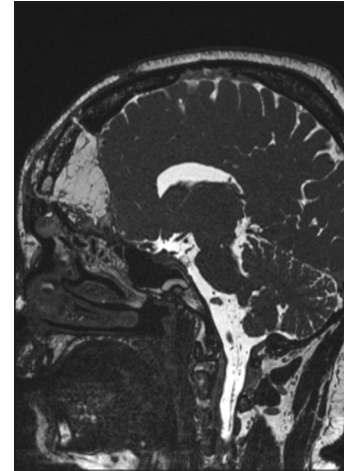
Three-month postoperative sagittal T2-CISS 3D magnetic resonance imaging showing the posterior ethmoidal space, filled with free fatty tissue and no residual or recurrent disease.
